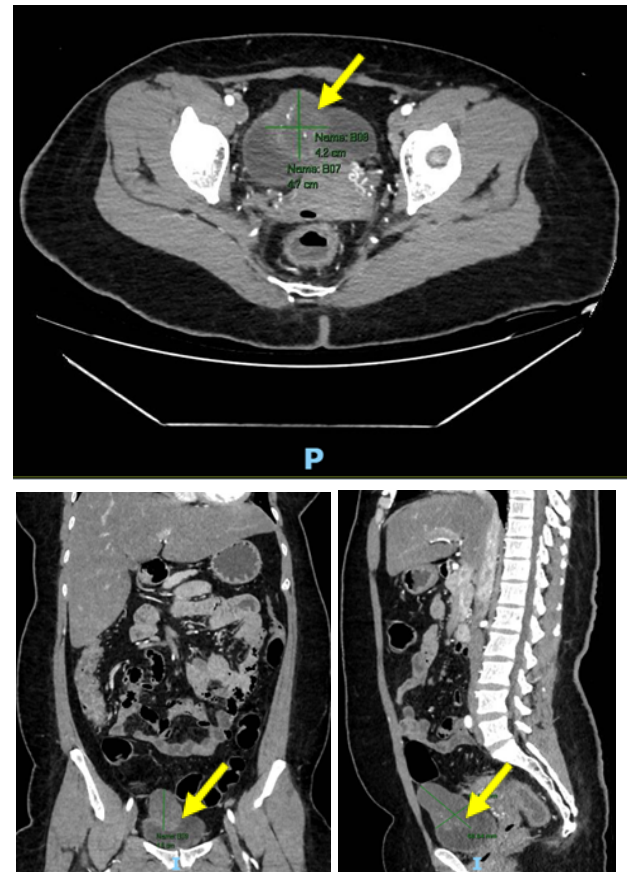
CT scan showing tumor at the vesica urinaria (yellow arrow)
